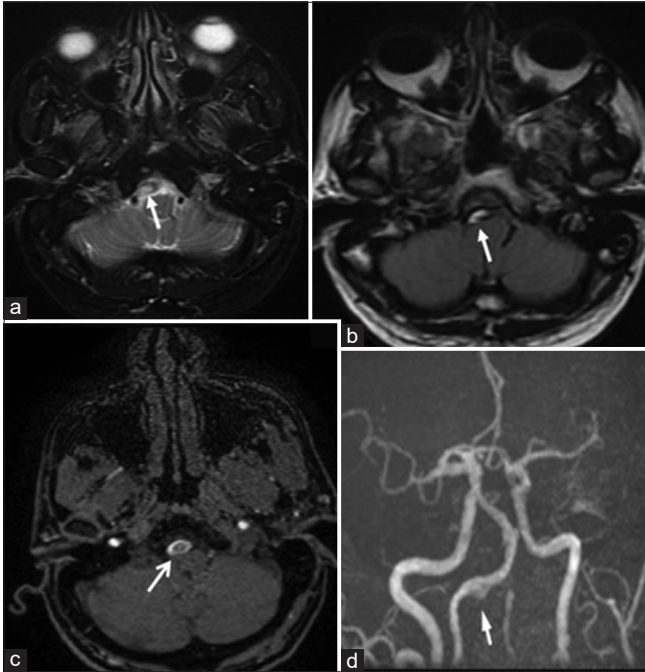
Partially thrombosed fusiform aneurysm. A 55 year old male presented with acute headache shows loss of flow void with mild fusiform dilatation (arrow) of the V4 segment of right vertebral artery on T2/T2 FLAIR images (a and b). Time of Flight (TOF) images (c and d) show peripheral partial flow with fusiform dilatation (arrow) of the V4 segment of the right vertebral artery.
